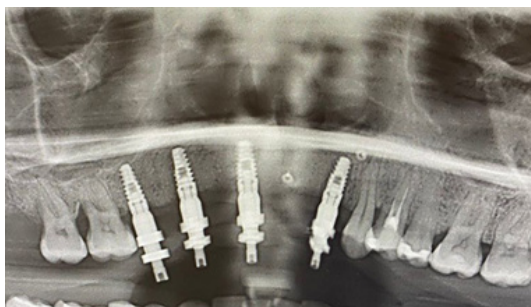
Panoramic X-Ray after verification jig fabrication.
